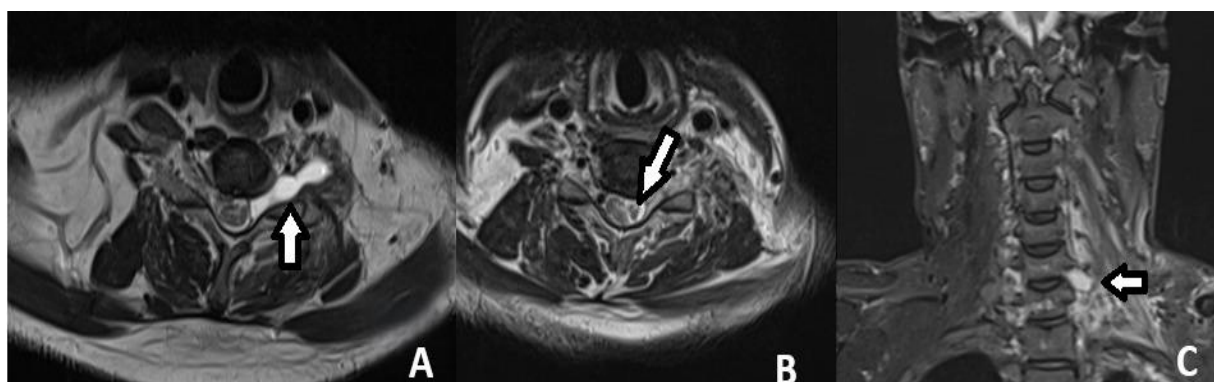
Magnetic resonance imaging demonstrating traumatic spinal nerve-root/trunk transection. Axial (A and B) and coronal (C) images show focal discontinuity of the cervical nerve-root/brachial plexus elements at the sites indicated by arrows.
